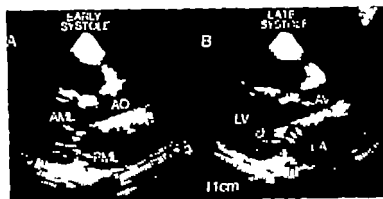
Cross-sectional echocardiograms (long axis frames) from Case 7. Panel A represents an early systolic frame and panel B represents late systolic frame. Note the convex curve of the anterior mitral leaflet towards the ventricle at late systole (small arrow in panel B).
